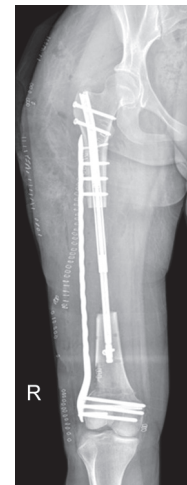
Immediate post-operative A/P femur radiograph demonstrating a PABST technique with a distal femur plate, fully extended antegrade Precice nail, and a distal femoral corticotomy prior to initiation of a retrograde transport
